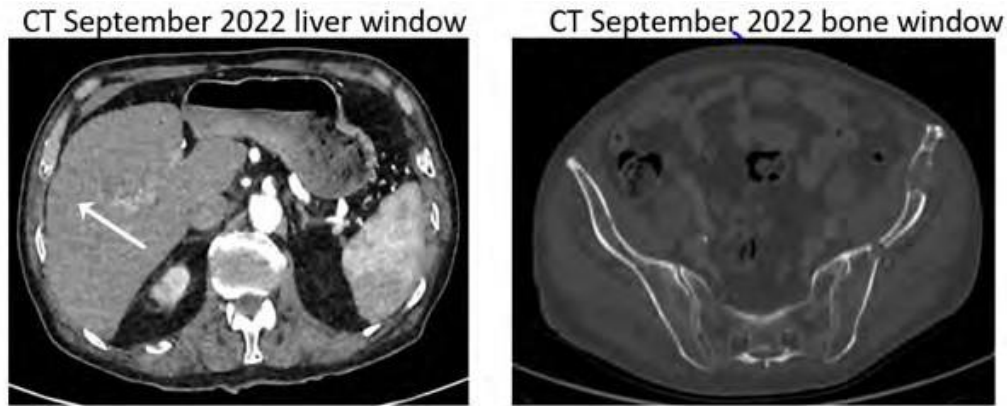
CT images August 2021 and September 2022 of liver and iliac bones demonstrating stable bony metastatic disease and reduced enhancement of segment 8 liver lesion.
